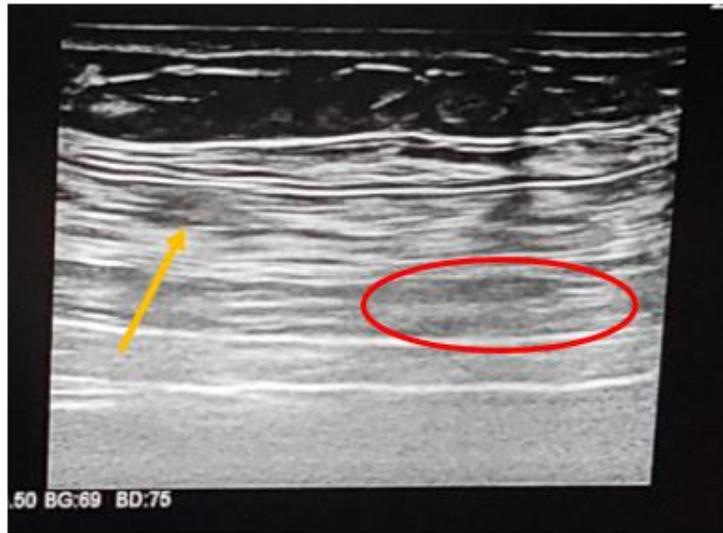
Botulinum Toxin type A injected into the lateral muscles under ultrasound guidance. Note the bubbles of diluted toxin into the internal oblique muscle (arrow) and transversus muscle
